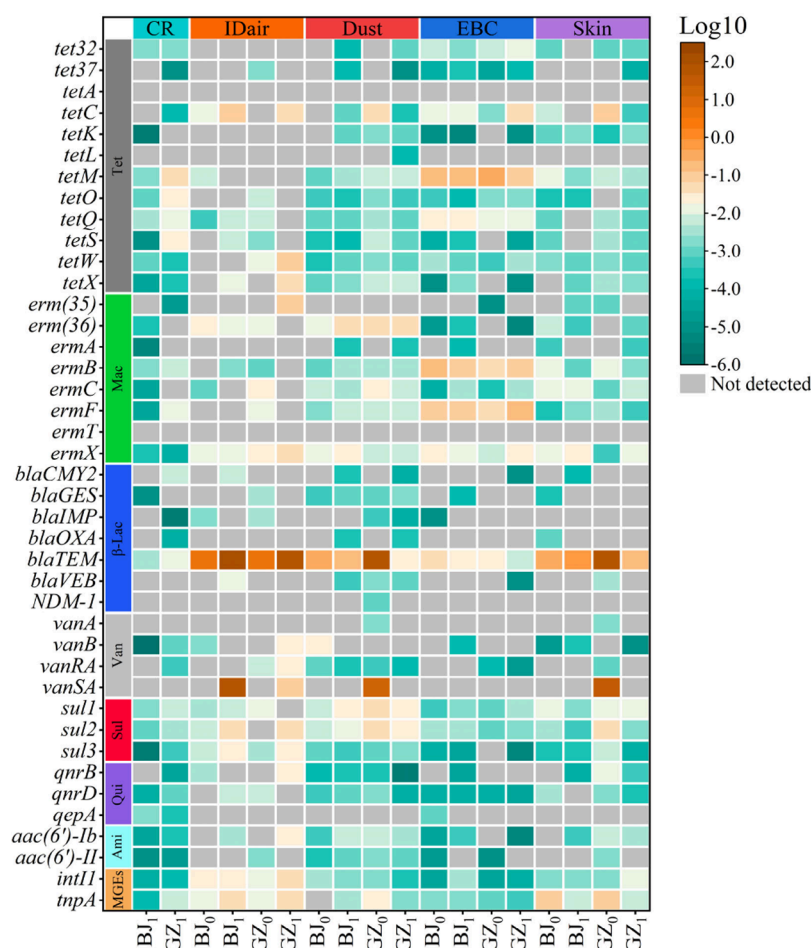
Relative abundance of the seven types of ARGs and MGE subtypes in cockroaches (CR), indoor environment (IDair: indoor air, Dust: floor dust), and human resident samples (EBC: exhaled breath condensate, Skin: forearm surface) using $2^{-\Delta\Delta CT}$ values. BJ: Beijing; GZ: Guangzhou. Subscripted number “1”: samples from cockroach-infested residences, “0”: samples from cockroach-free residences.
